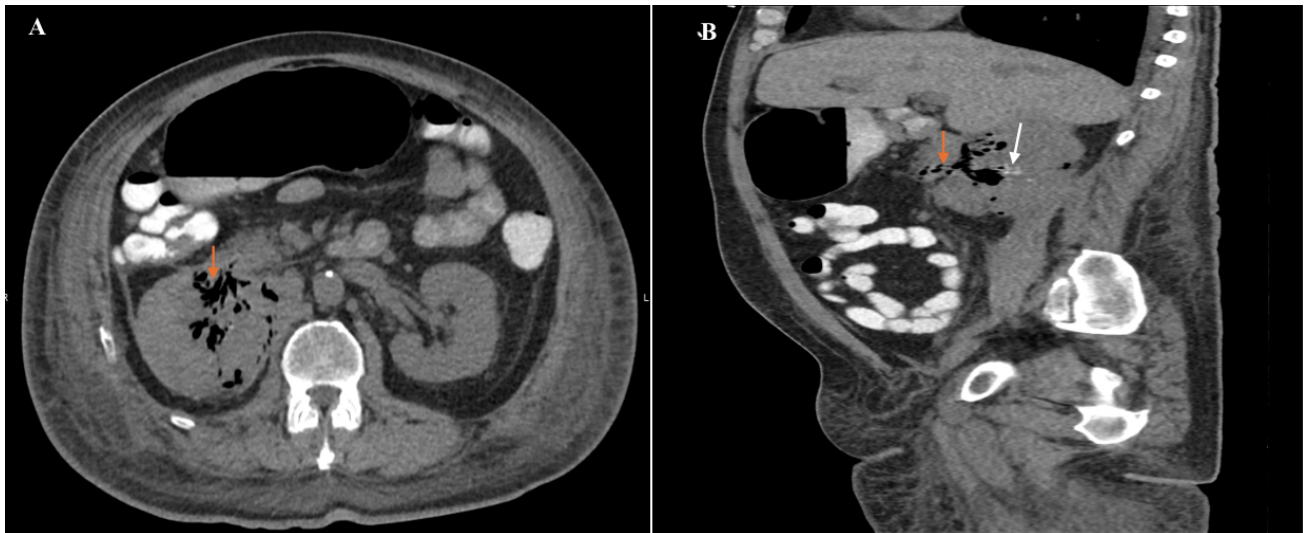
(A) Axial view of contrast-enhanced computerized tomography (CT) scan of the abdomen showing right renal mass with emphysema in the right kidney (orange arrow) communicating with the duodenum. (B) Sagittal view showing fistulization with duodenum (orange arrow) and the focus of oral contrast within the kidney (white arrow), confirming fistulization.
